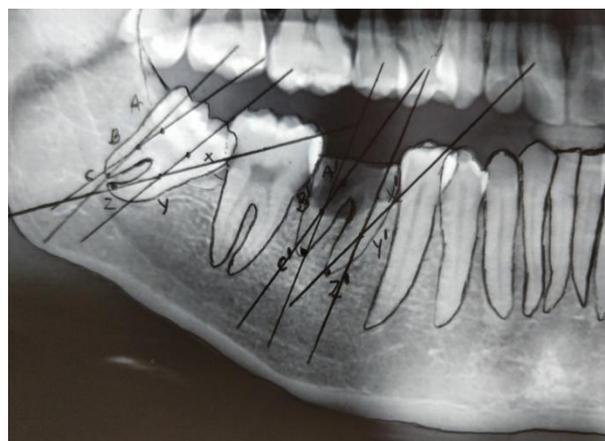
Radiographic analysis in case 2
